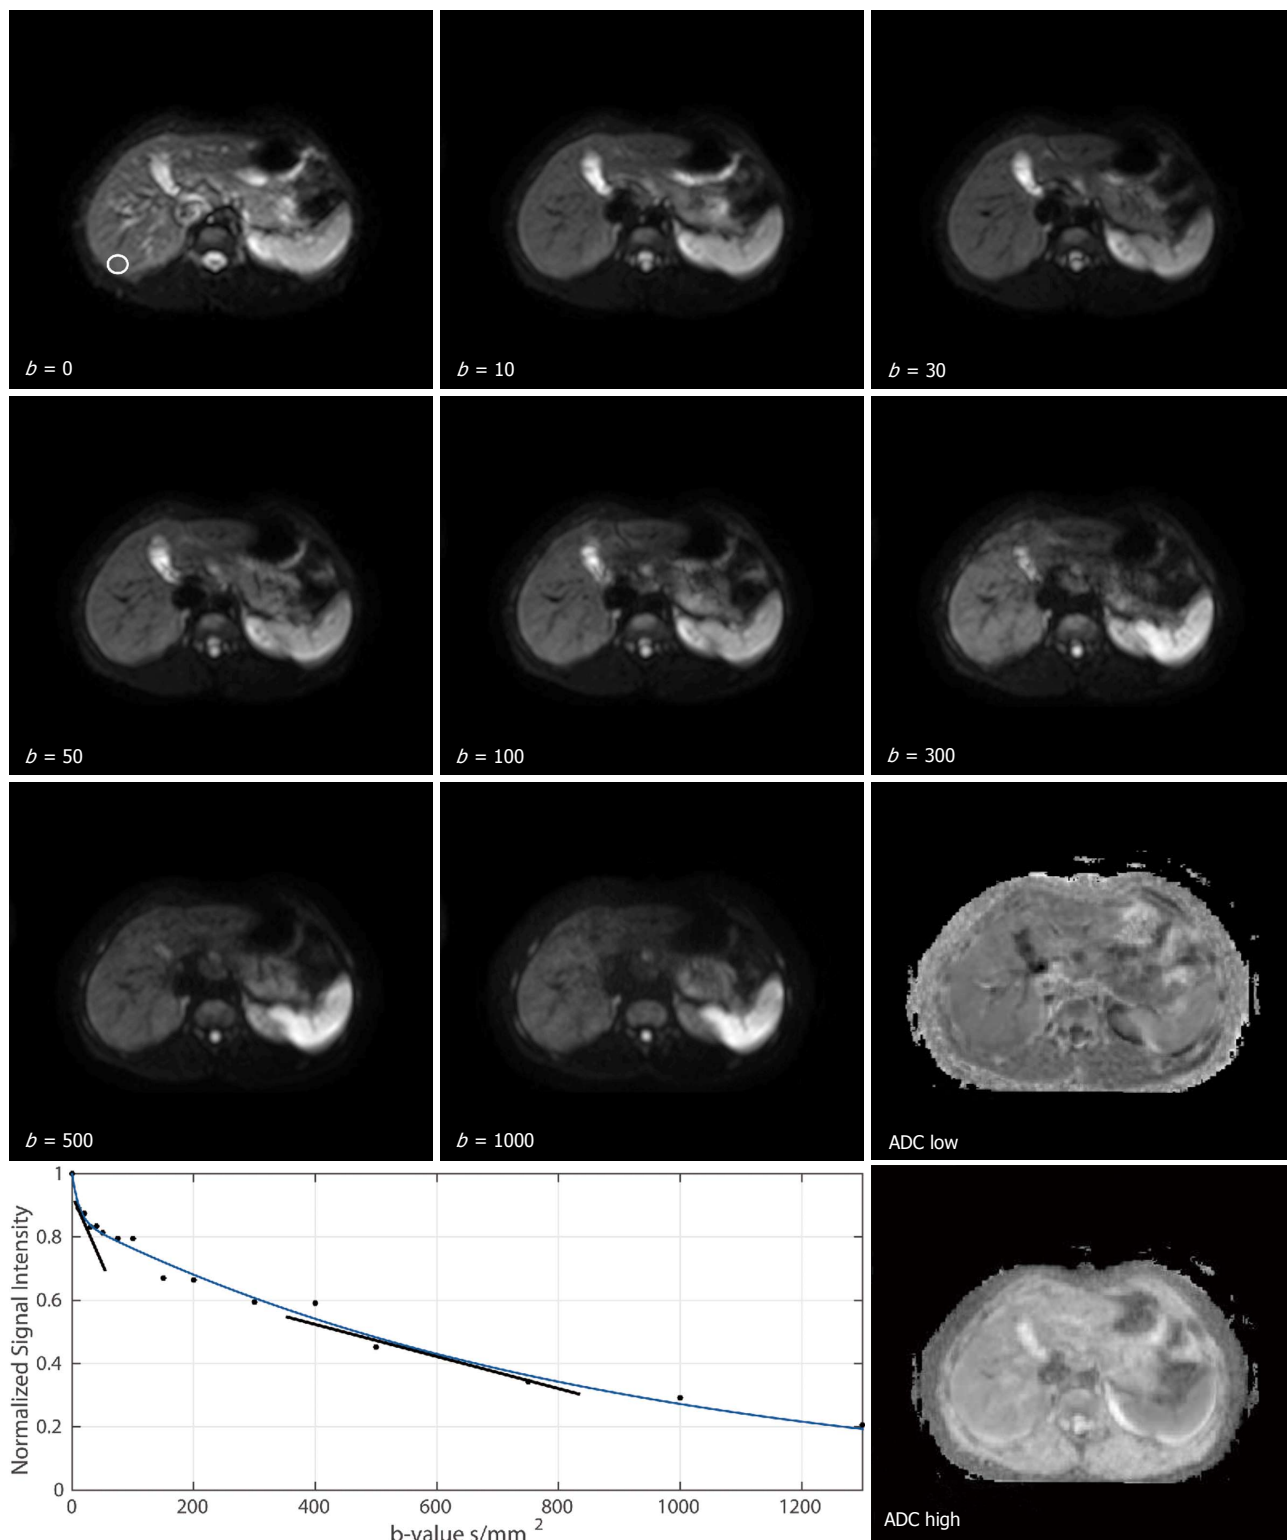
Diffusion-weighted magnetic resonance images of the abdomen of a healthy 25-year-old male volunteer at different b -values of 0, 10, 30, 50, 100, 300, 500, 1000 s/mm^2 . An ROI placed over a non-heterogeneous region in the liver is shown on the $b = 0 \text{ s/mm}^2$ image. A bi-exponential fit to the ROI drawn on the diffusion-weighted-magnetic resonance data acquired with b -values of 0, 10, 20, 30, 40, 50, 75, 100, 150, 200, 300, 400, 500, 750, 1000 and 1300 s/mm^2 is also shown where the slopes of the exponents represent the fast diffusion component (which includes perfusion) and the slower diffusion component. Quantitative apparent diffusion coefficients maps are also shown where ADC low was computed with b -values $\leq 100 \text{ s/mm}^2$ and ADC high was computed with b -values $\geq 150 \text{ s/mm}^2$. ROI: Region-of-interest; ADC: Apparent diffusion coefficient.
